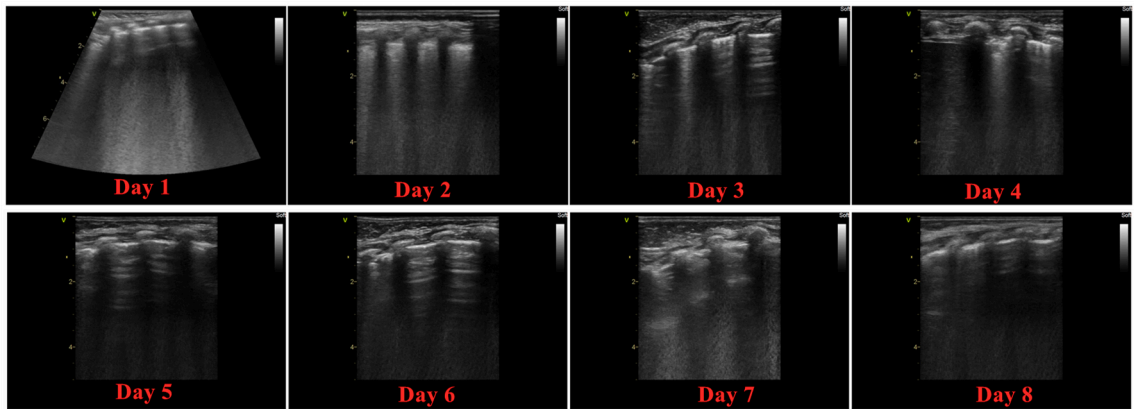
Changes in pulmonary ultrasound scores during ECMO treatment.
